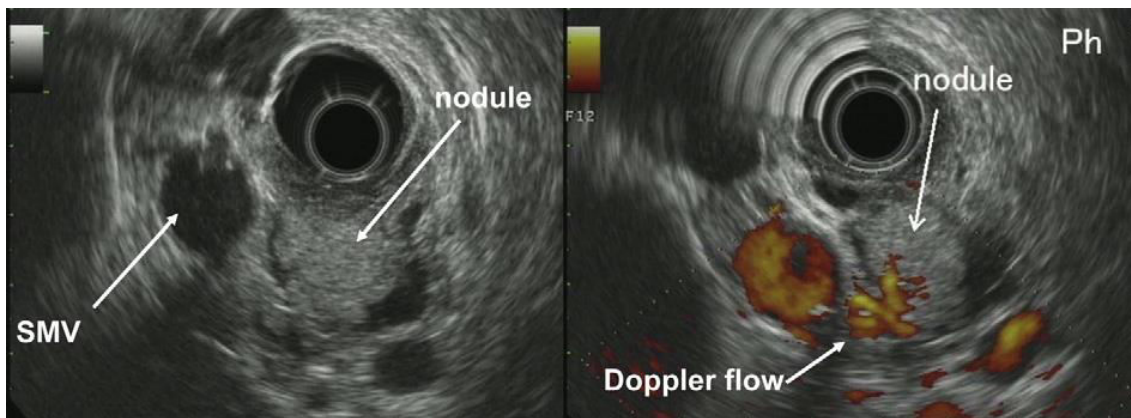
EUS showing a mural nodule in the dilated MPD with Doppler flow indicating the presence of a blood supply (25).
